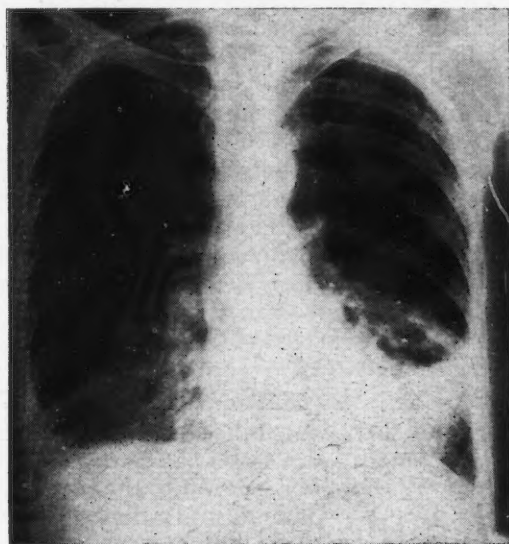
Chest radiograph on May 28. Fig. 2.—Chest radiograph on June 7.
